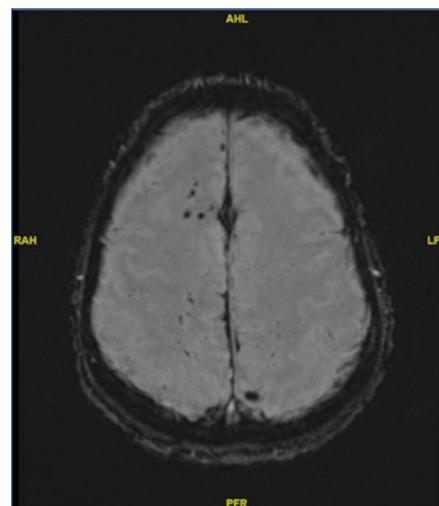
SWI MRI images with microhemorrhages in the bilateral cerebral hemispheres, consistent with diffuse axonal injury.
